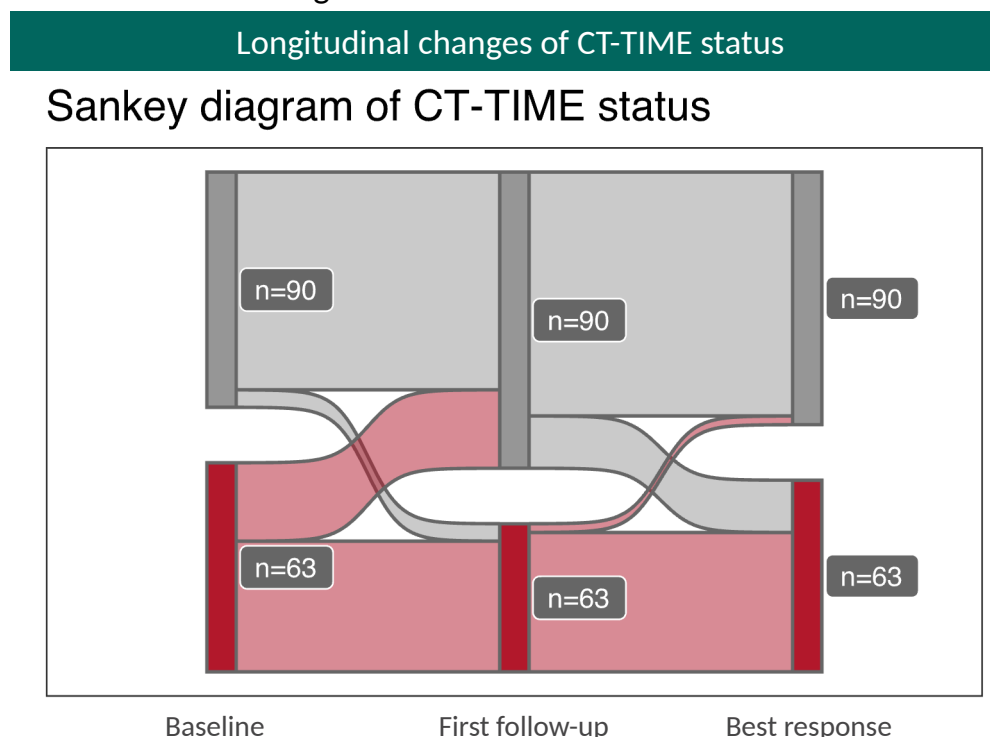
Spatiotemporal analysis of CT-TIME in cohort 4. (A) Exploration of CT-TIME score heterogeneity across tumor types and locations. Aggregation of per-tumor CT-TIME scores to the patient level and translation to CT-TIME status. (B) Longitudinal change in CT-TIME status. TIME, tumor immune microenvironment.
